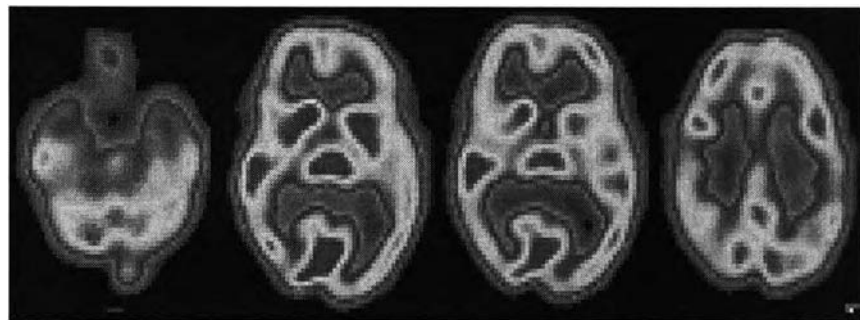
Brain scan using SPECT at King Chulalongkorn Memorial Hospital
